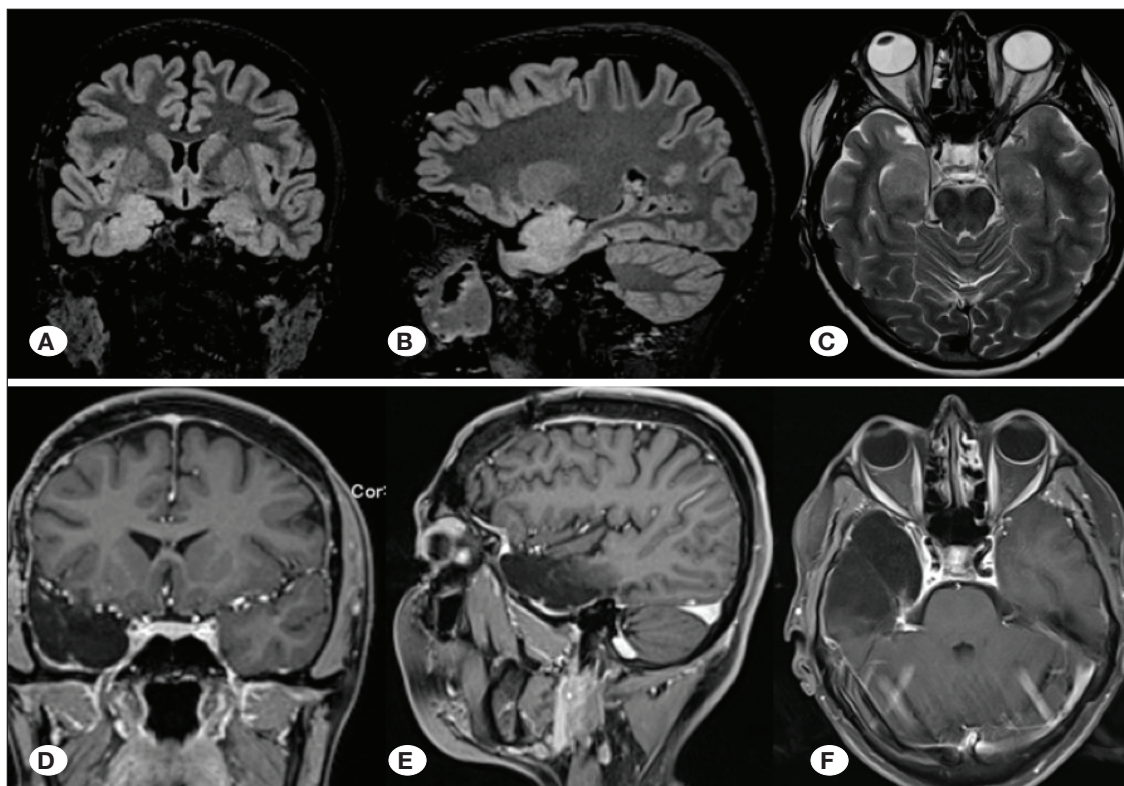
A-C) Preoperative brain magnetic resonance imaging (MRI) sections (A: double inversion recovery coronal, B: double inversion recovery sagittal, C: T2W axial) of patient #5; D-F) Postoperative T1-weighted contrast-enhanced MRIs (D: coronal, E: sagittal, F: axial) of patient #5.
